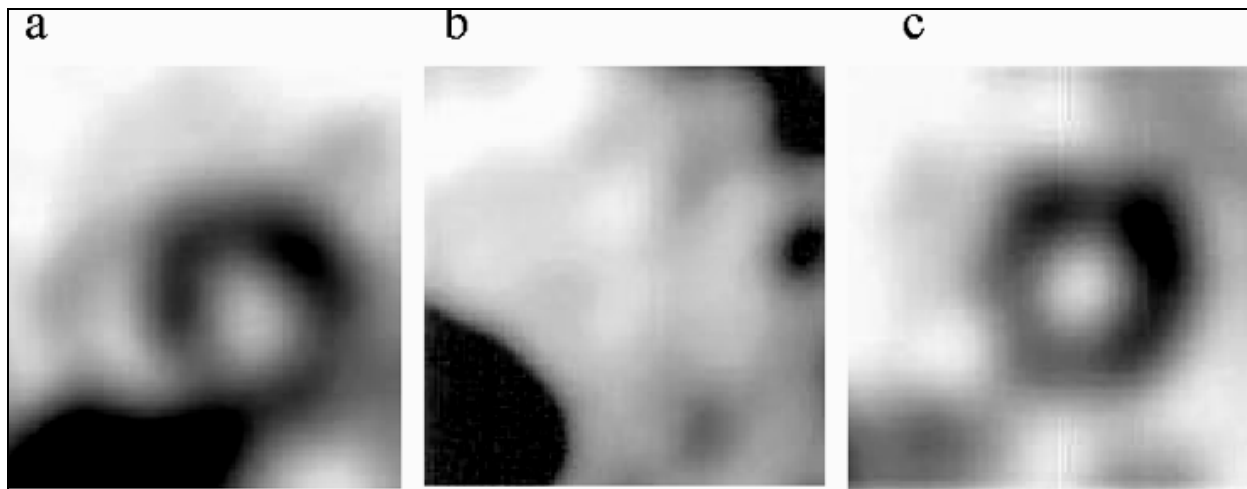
Short-axis views of  $^{123}\text{I}$ -MIBG myocardial scintigraphy
